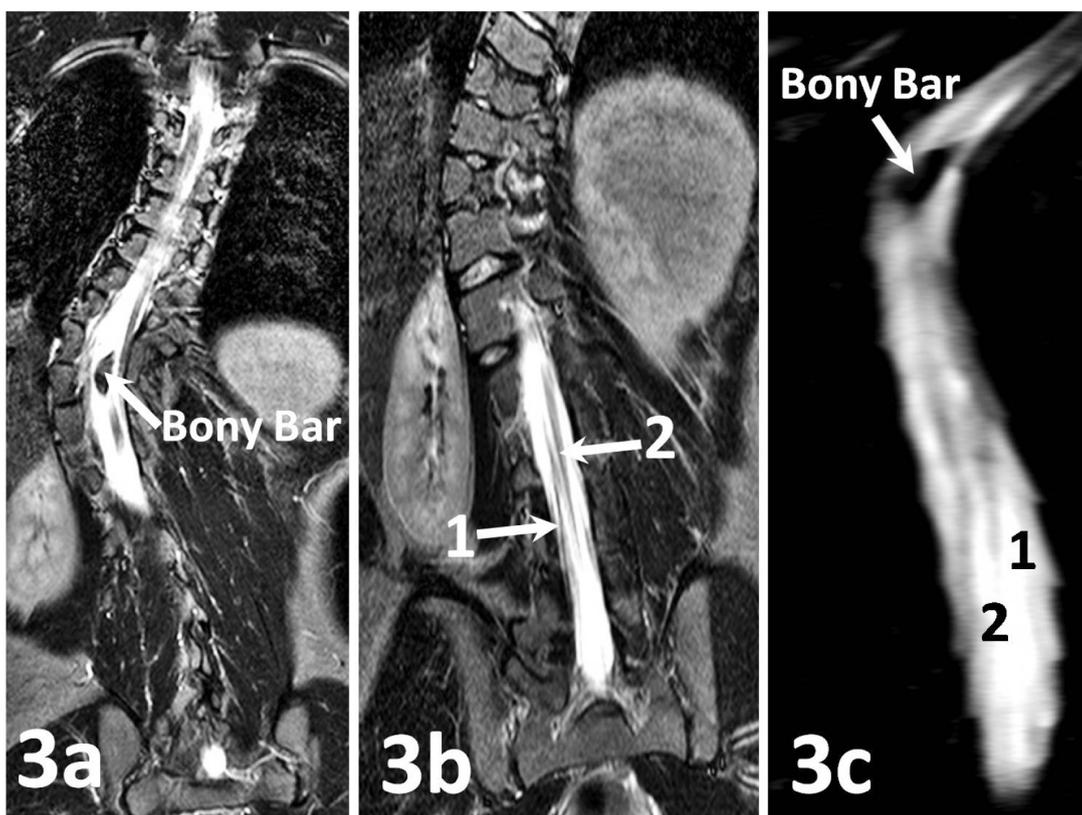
Coronal MRI images (Figure 3a, 3b and 3c) not only showed the bony bar, but in addition demonstrated that the split hemicords diverged distally and did not fuse, thus confirming the diagnosis of diplomyelia. No meningocele was seen. Lower thoracic and upper lumbar spinal segmentation and fusion abnormalities are seen along with a scoliosis having concavity towards left.
